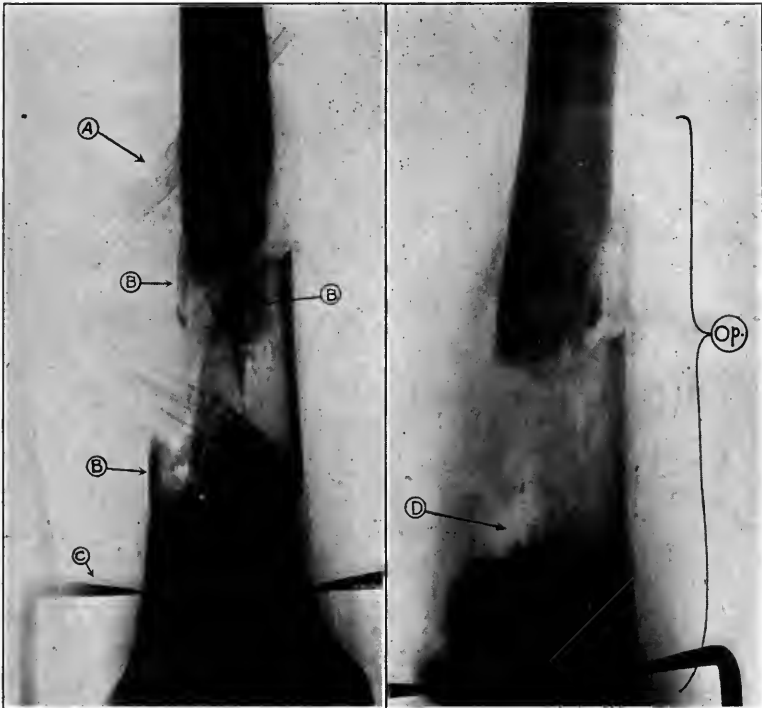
X-rays of chronic osteomyelitis and multiple sequestra. When first seen four months after the wound there was only anterior drainage so that each day pus pooled in the fracture cavity. The case had been treated by Carrel's tubes (A). The arrows marked B indicate sequestra. C indicates caliper points embedded in periosteal callus. After radical operation the entire cancellous tissue within the condyles was found full of pus and necrosed trabecular tissue and chronic osteomyelitis extended three inches up the shaft. All this necrosed bone was removed and posterior dependent drainage was established. The wounds healed within a month and the second x-ray shows the bone condition at that time. Note the homogeneous character of the callus. The light area marked D was the seat of dependent drainage. Two large tubes were used as in Fig. 160.
